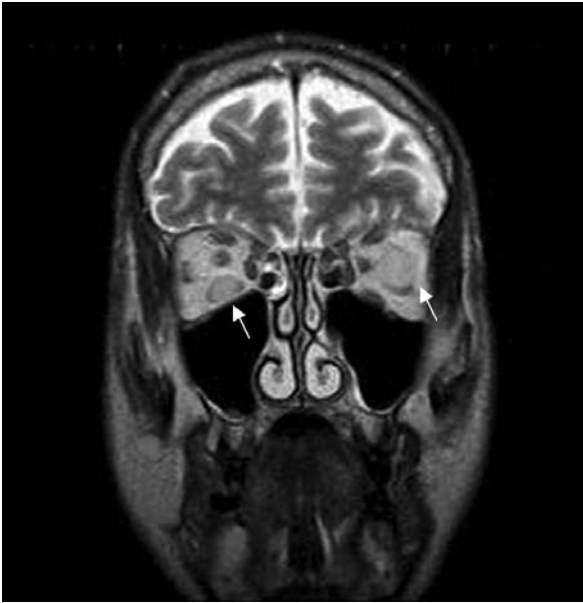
T2-weighted image in coronal plane shows bilateral orbital masses (white arrows) with enlarged inferior rectus muscle on the right side.
